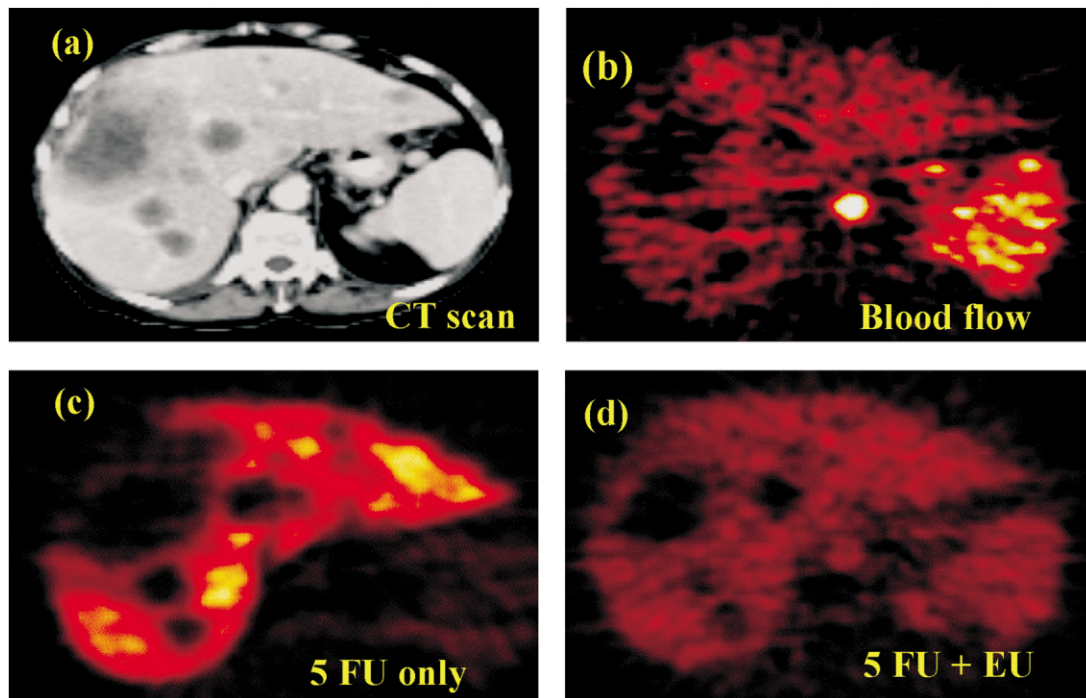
Typical transabdominal Computed Tomography (CT) (a) and corresponding Positron Emission Tomography (PET) blood flow (b) and PET  $^{18}\text{F}$ -fluorouracil images without eniluracil (EU) (c) after eniluracil (d), showing liver, spleen and multiple hepatic metastasis (reprinted with permission from Elsevier Science (*Lancet* 2000 355 2128)).
